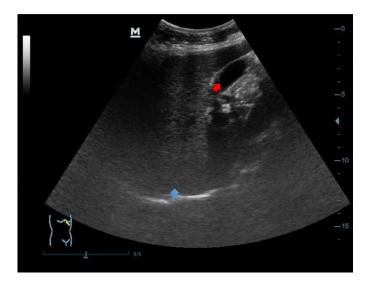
A longitudinal sonogram of the left hypochondriac region showing the liver (blue arrow) and gallbladder (red arrow) on the left side instead of the normal anatomical position.
